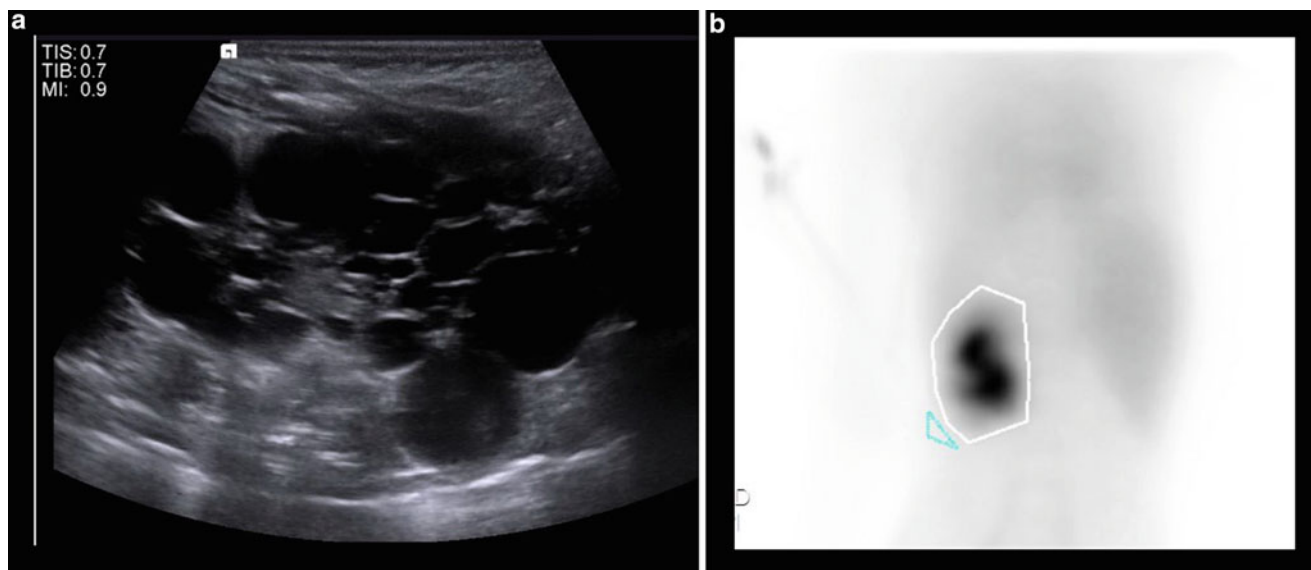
Renal ultrasound showing characteristic features of multicystic dysplastic kidney. (a) Multiple cysts of variable size are present with no apparent normal renal parenchyma. (b) DMSA study showing
